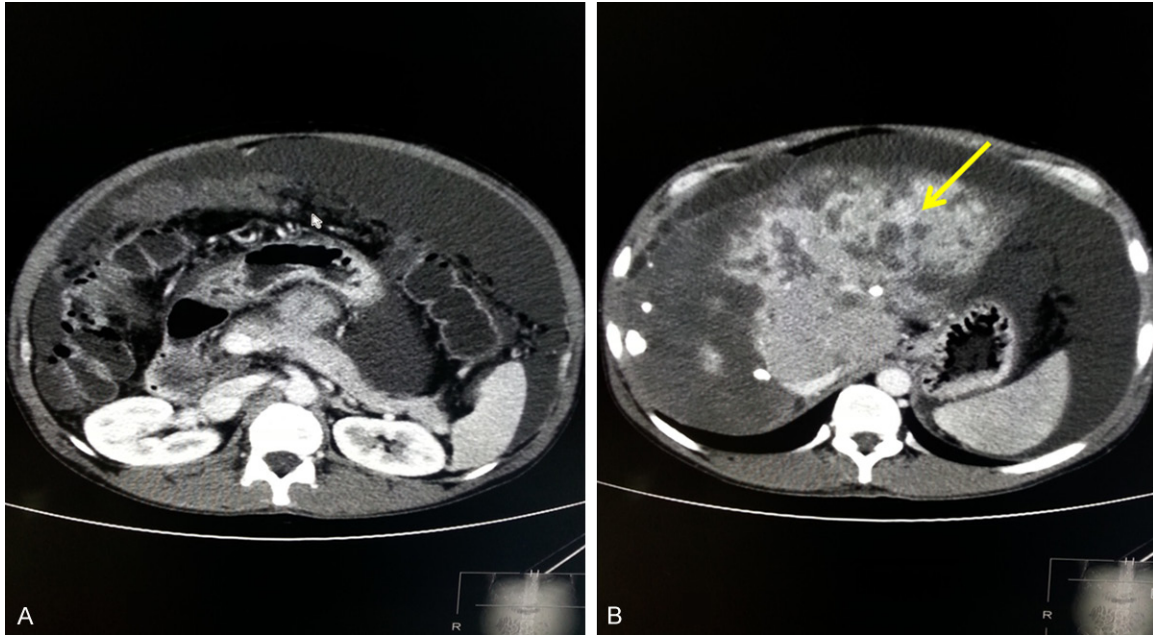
A. Computed Tomography scan of the abdomen demonstrate massive peritoneal thickening, nodular change and a large intraperitoneal effusion. B. A large number of nodules within the liver can be seen, low-density mass lesions (arrow) with intraperitoneal effusion.
